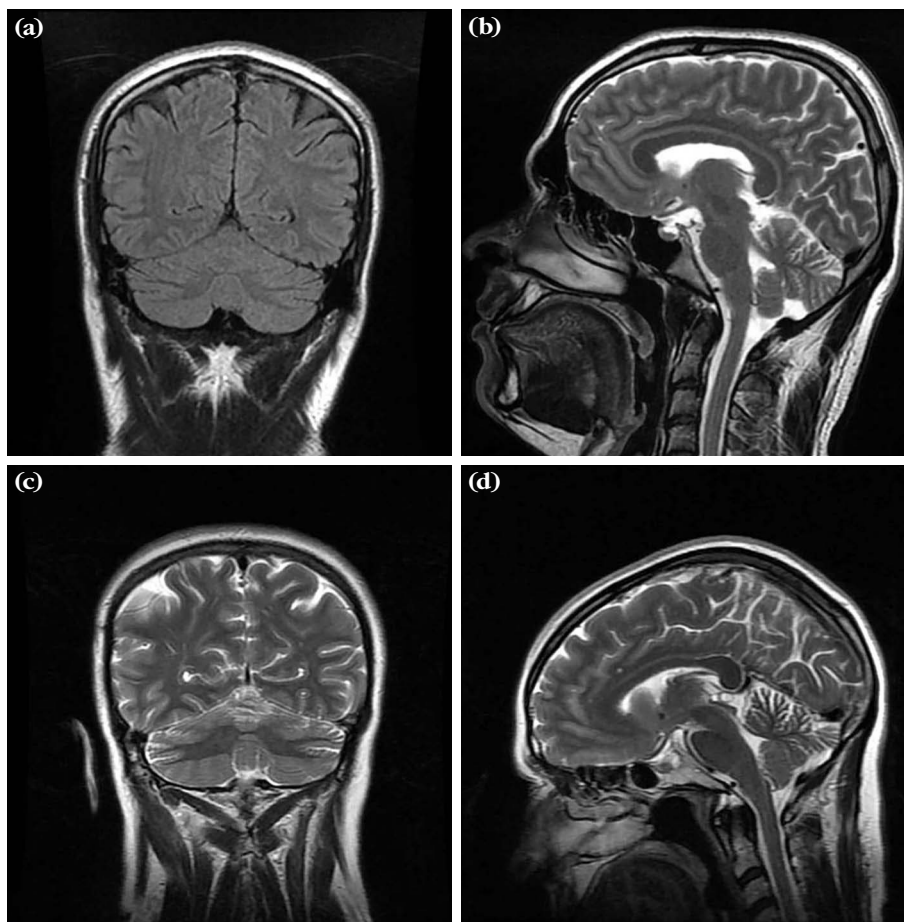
(a, b) The magnetic resonance imaging of the patient and (c, d) his mother demonstrating the cerebellar atrophy.
